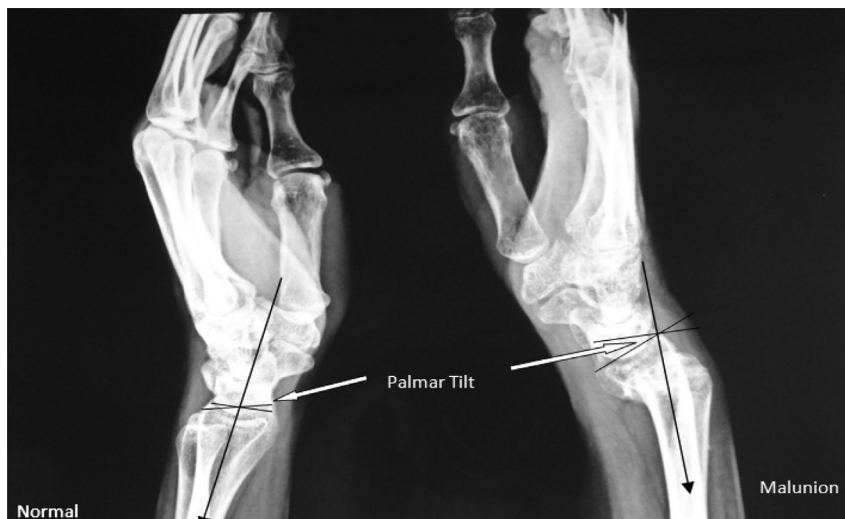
Radiograph of patient hands with wrist <50 years of age (Lat. view).
